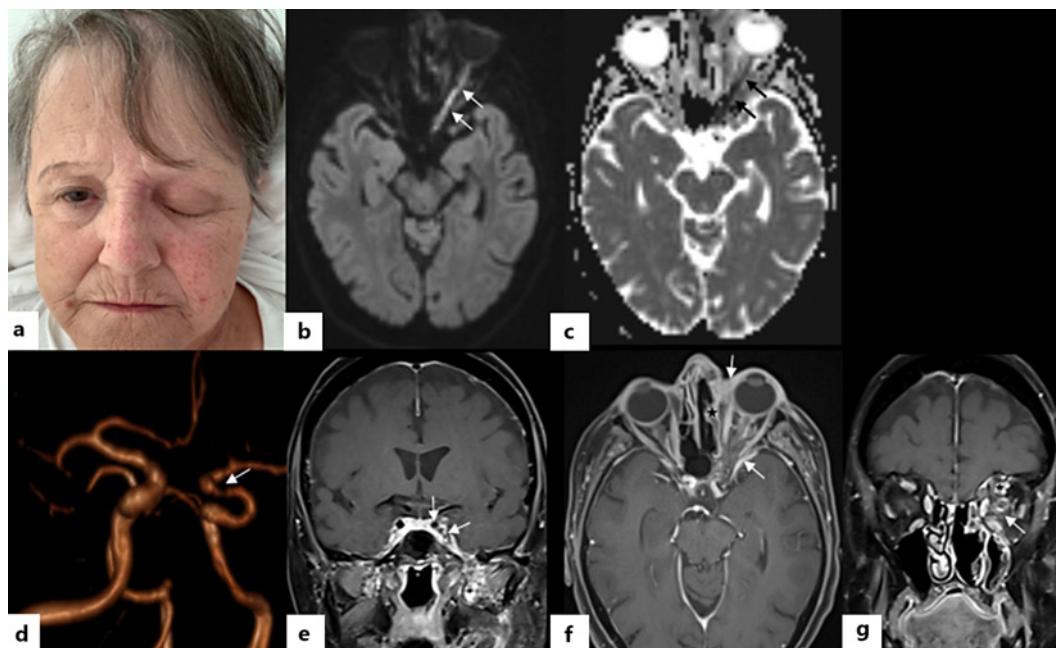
Patient 1: initial clinical examination and initial in-house MR scan. a Clinical appearance at first examination at our hospital, presenting with left face and eyelid swelling, diffuse erythema, and ophthalmoplegia. DWI (b) with corresponding ADC (c) revealed diffusion restriction of left optic nerve (arrows) indicative of optic nerve ischemia. d. Reduced left internal carotid artery (ICA) caliber indicative of secondary vasculitis (compare white arrow in the 3D reconstruction of the 3D-time of flight angiography [3D-TOF MRA]). The T1-weighted coronal (e, g) and axial (f) starVIBE with fat saturation after administration of contrast showed the left cavernous sinus thrombosis with reduced flow void of the ICA (white arrows in e). The left extraocular muscles were edematous with enhancement (see arrow in f and black star in g) as with myositis. The left optic nerve showed significant enhancement (arrow in g). There was a frank osseous destruction of the left paranasal sinus with mucous retention in the anterior ethmoid (black star in f) and imaging appearance of an “empty nose” on the left side in side comparison (f, g).
